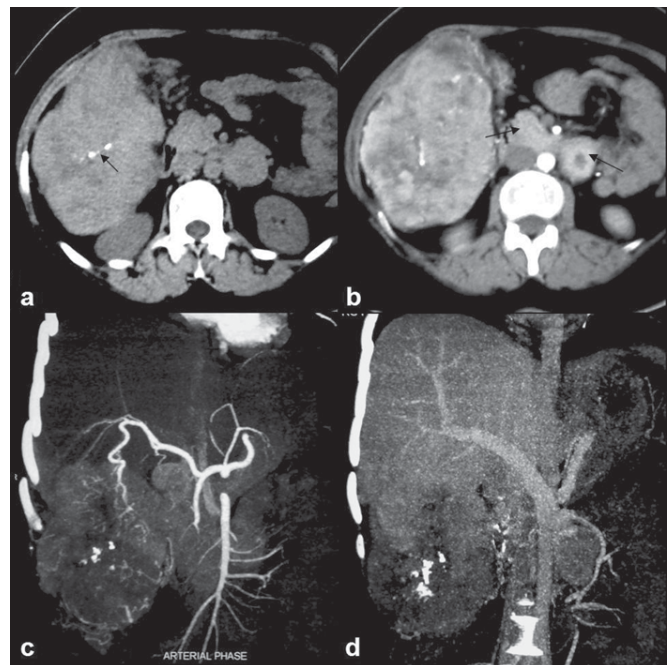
A non-contrast CT image of the same patient as in FIG 17 (a) shows presence of calcification within the scar. Arterial phase image (b) at a different level shows an intensely enhancing mass as well as similar morphology retroperitoneal lymph nodes (arrows) suggestive of nodal metastases. Maximum intensity projection images in the arterial (c) and venous (d) phases demonstrate the relationship of the mass with branches of the hepatic artery and portal vein.
